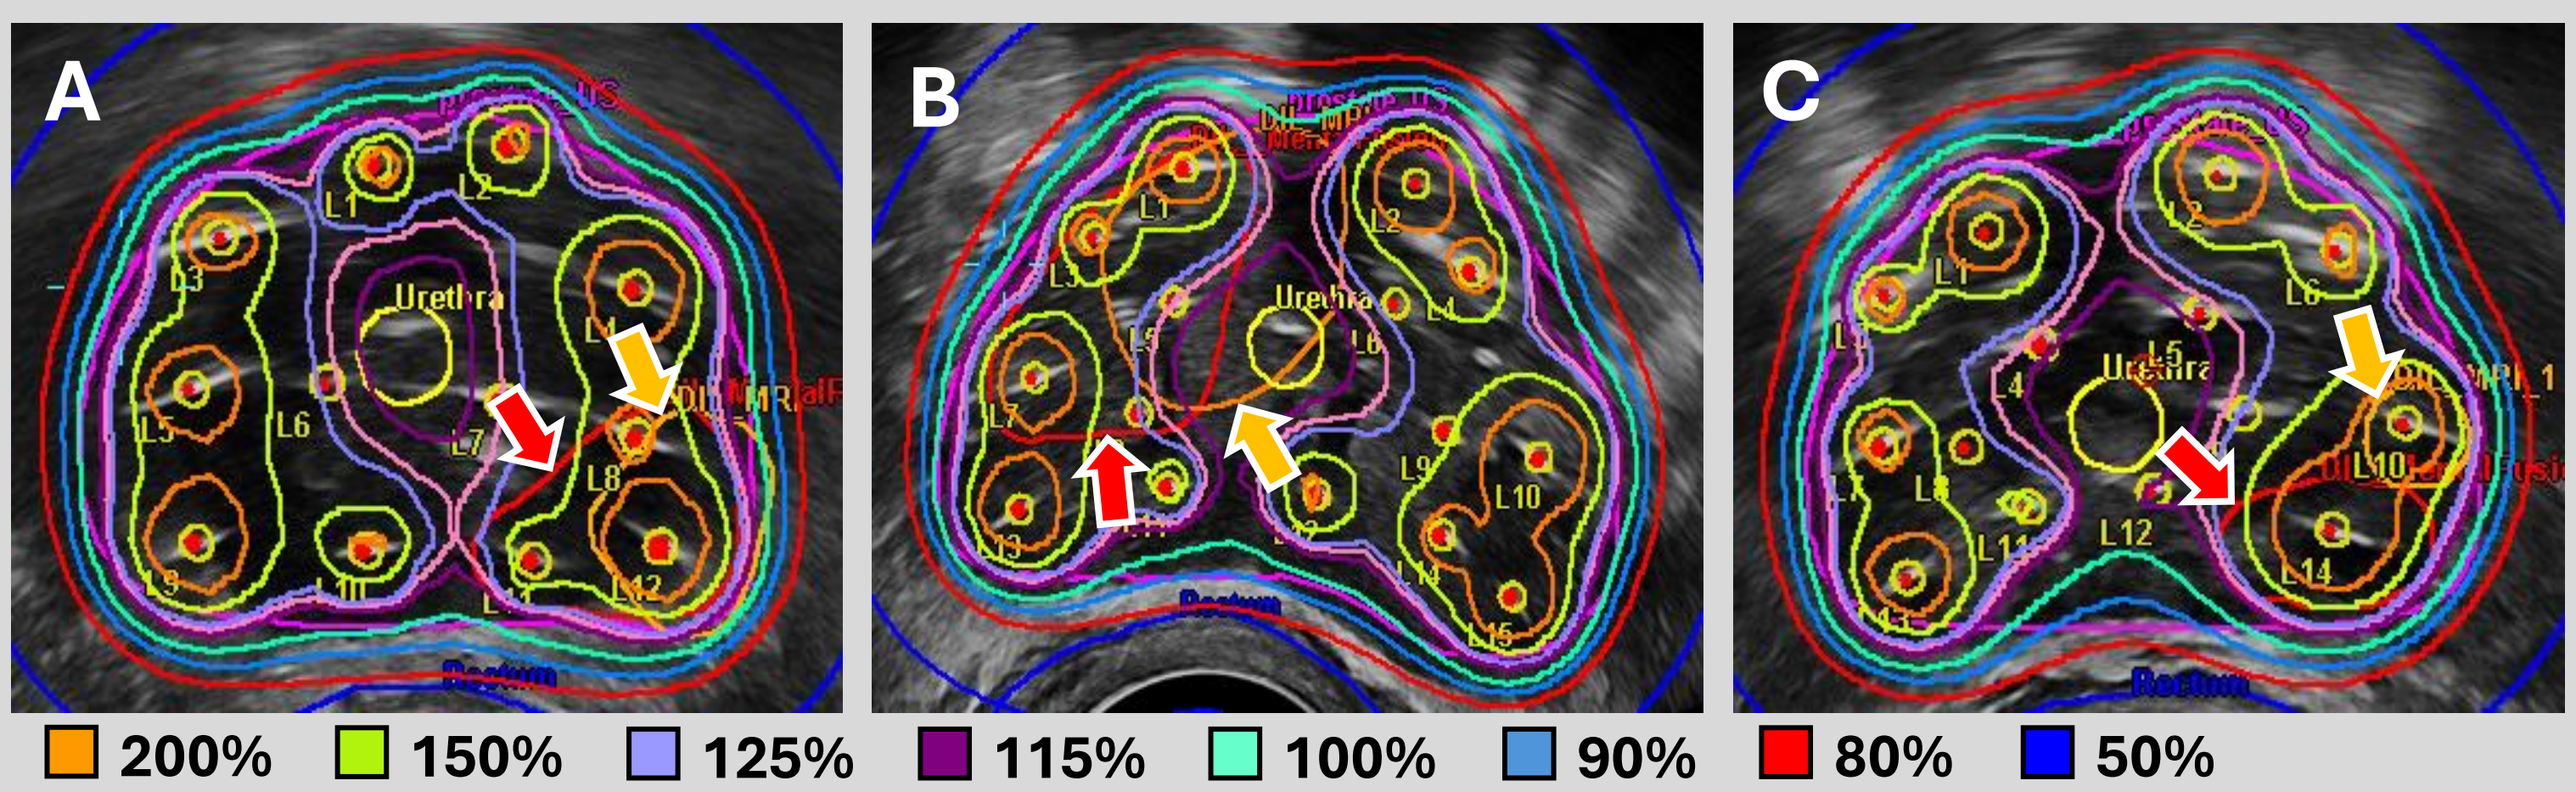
Isodose distributions for the same 3 retrospective clinical cases showing the clinical treatment plan recalculated with the mentally fused DIL (red arrows) and deformed MR-defined DIL (orange arrows) displayed on the ultrasound image.
